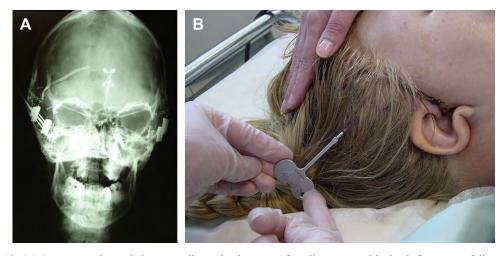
(A) Anteroposterior cephalogram radiograph taken to confirm distractor positioning before onset of distraction phase. (B) Distractor key used to activate internal distractor that is accessible by a trancutaneous rotation arm.
